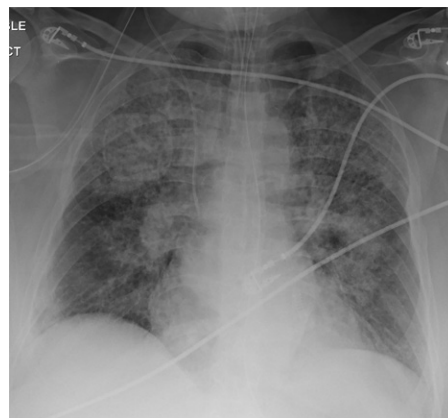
HMPV pneumonia in a 56-year-old woman with severe shortness of breath, cough, and fever who required treatment with respiratory support at hospital admission. Anteroposterior chest radiograph shows bilateral upper lobe predominant near-consolidative opacities involving both lungs. Bacterial microorganisms were not found. Test results confirmed HMPV pneumonia.
